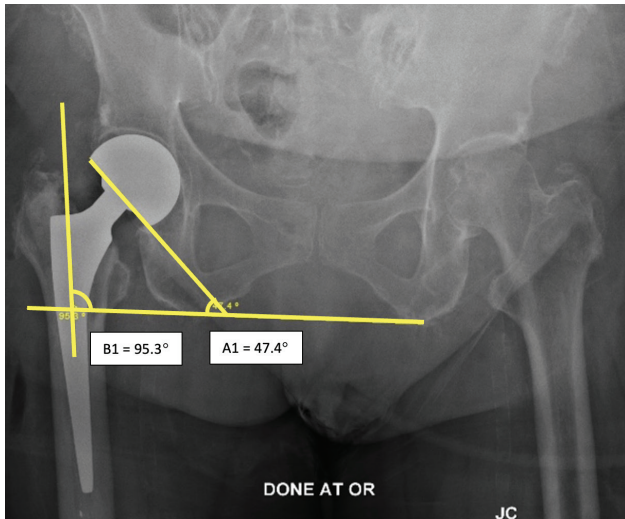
Hip neutral AP x-ray.
